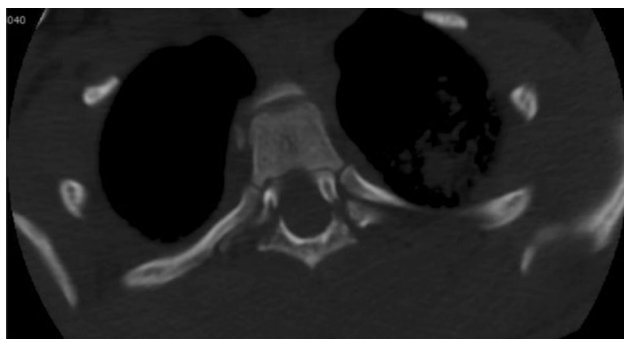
CT axial view showing the chance fracture lines
